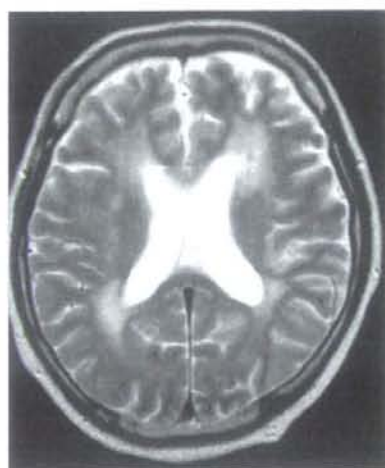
Brain MRI (T<sub>2</sub> weighted image) of case 4
